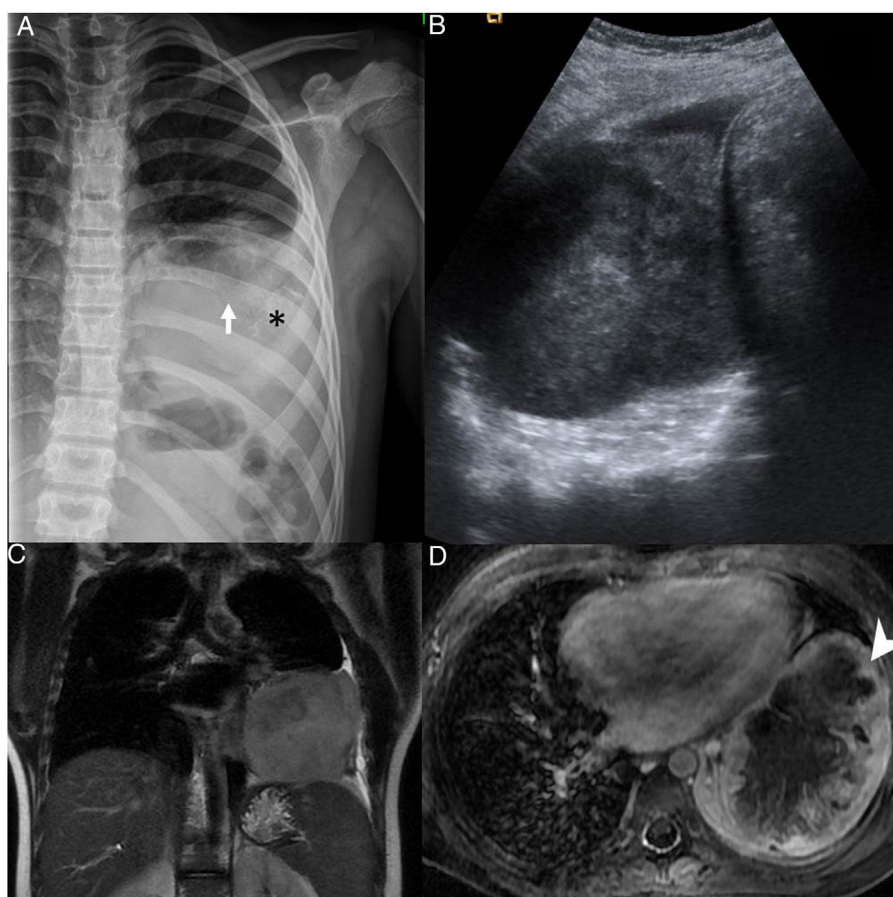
(A) Radiograph of the ribcage showing infiltration and partial destruction of the posterior shaft of the left 8th rib (white arrow) associated with a large intrathoracic, extrapulmonary soft-tissue mass with faint amorphous calcifications (*) and mild pleural effusion. (B) Ultrasound image of the heterogeneous mass in the thorax. (C) T2-weighted magnetic resonance imaging (MRI), coronal plane and (D) intravenous contrast-enhanced, fat-saturated T1-weighted MRI, transversal plane, showing a lobulated mass in contact with the mediastinal, pericardial, axillary and diaphragmatic pleura with peripheral enhancement (arrow point) and necrosis in the central area.
